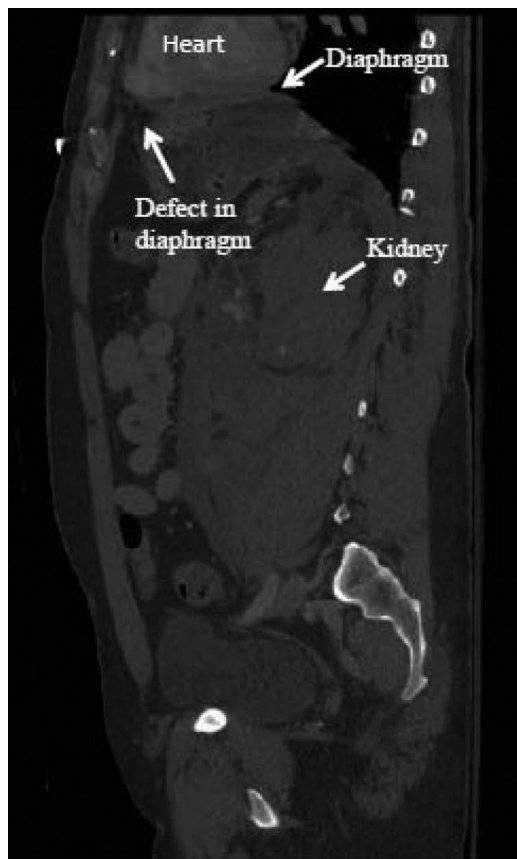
CT scan of abdomen and pelvis on day of injury.
